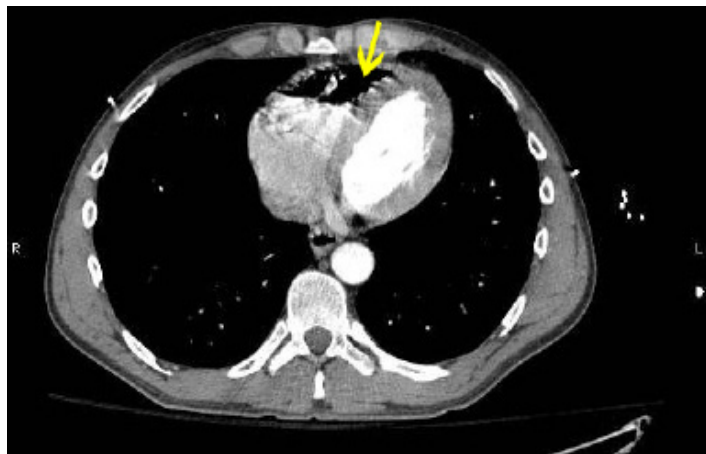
Computed tomography of the thorax with intravenous contrast demonstrates a large right ventricular air embolus.
